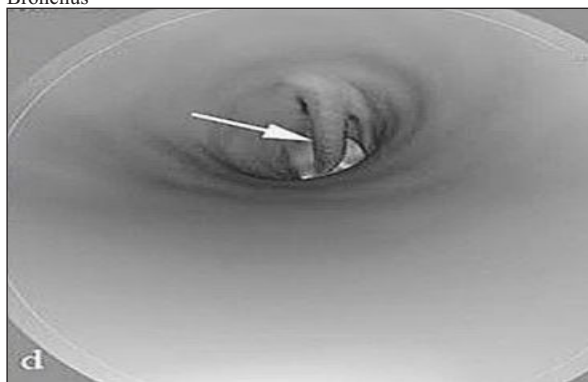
Patient's CT Scan Showing 3D Reconstruction Of FB In Bronchus
